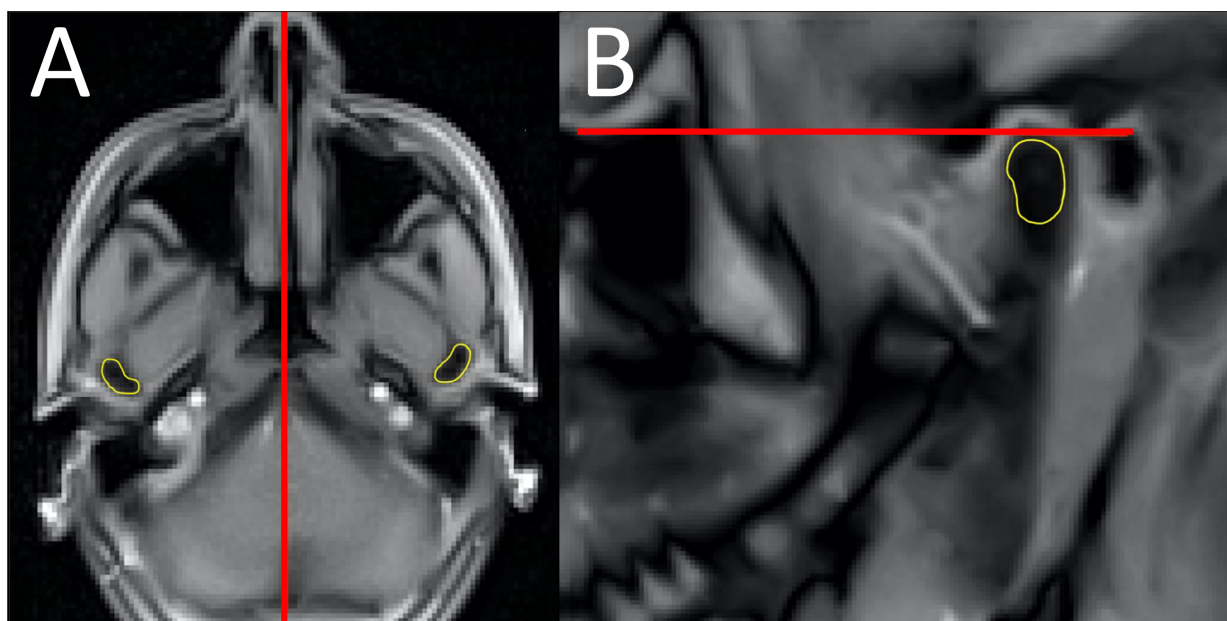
MRI visualization of manually segmented mandibular condylar heads with anatomical reference planes. (A) Axial image showing the manually segmented right and left condylar heads (yellow) and the intersection of the mid-sagittal reference plane with the axial image (red line). (B) Sagittal image with the manually segmented condylar head (yellow) and the intersection of the Frankfurt horizontal plane with the sagittal image (red line).
